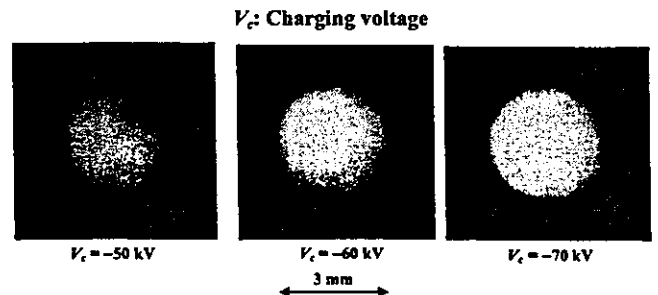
Images of the x-ray source of $K\alpha$ lines obtained using a pinhole camera with changes in the charging voltage.
